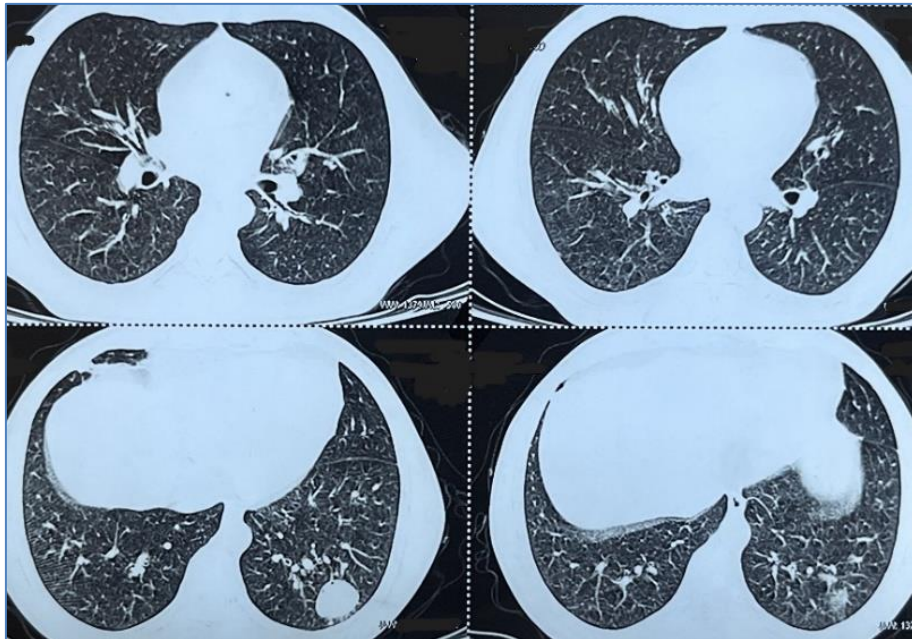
HRCT thorax showing round consolidation in left lower lobe posterior basal segment with normal lung parenchyma
